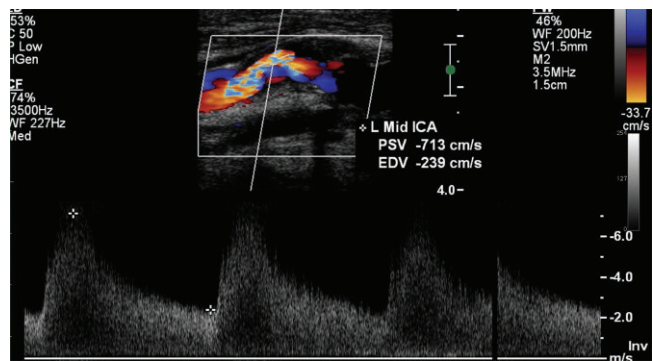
Spectral duplex Doppler at the site of maximal ICA velocity demonstrates plaque, color narrowing and aliasing, and elevated ICA velocities. The peak systolic velocity is 713 cm/s and the end-diastolic velocity is 239 cm/s.
